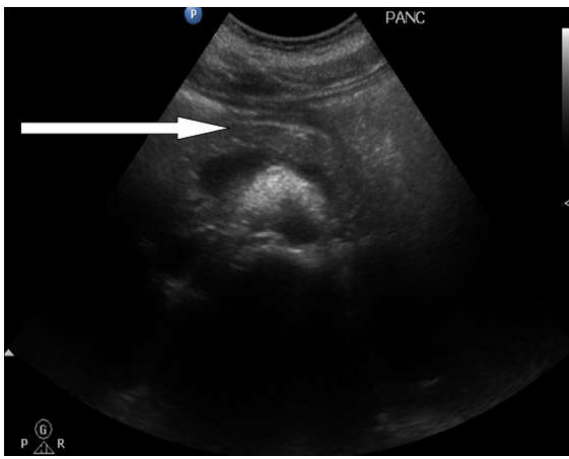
Ultrasound Abdomen With Normal Pancreas
